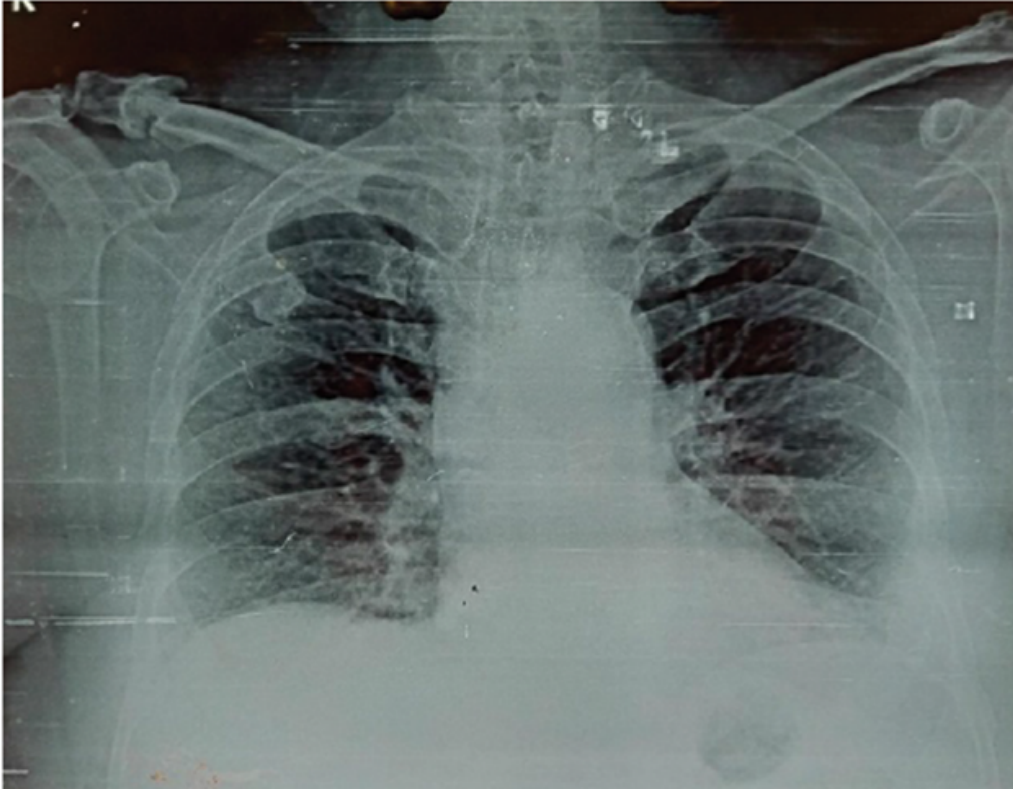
X-Ray chest (PA view) showed fracture of right clavicle.
